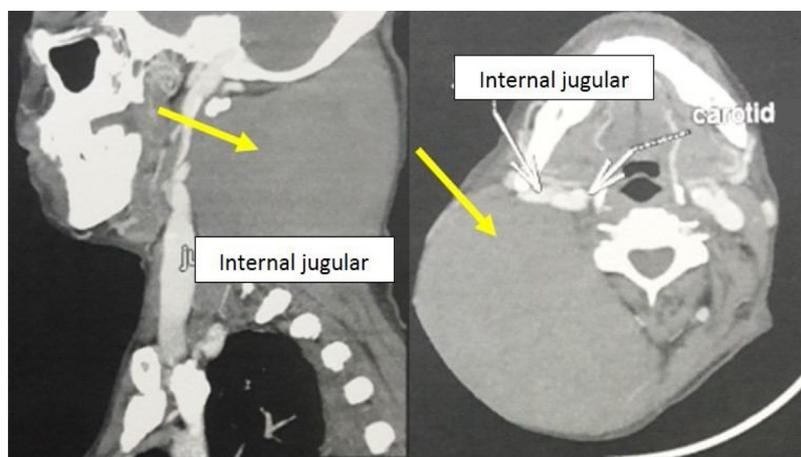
Computed tomography scan of the neck showing a soft tissue mass in the upper neck lateral to the sternocleidomastoid muscle, infiltrating the deep lateral neck muscles and surrounding superficial and deep fat.
